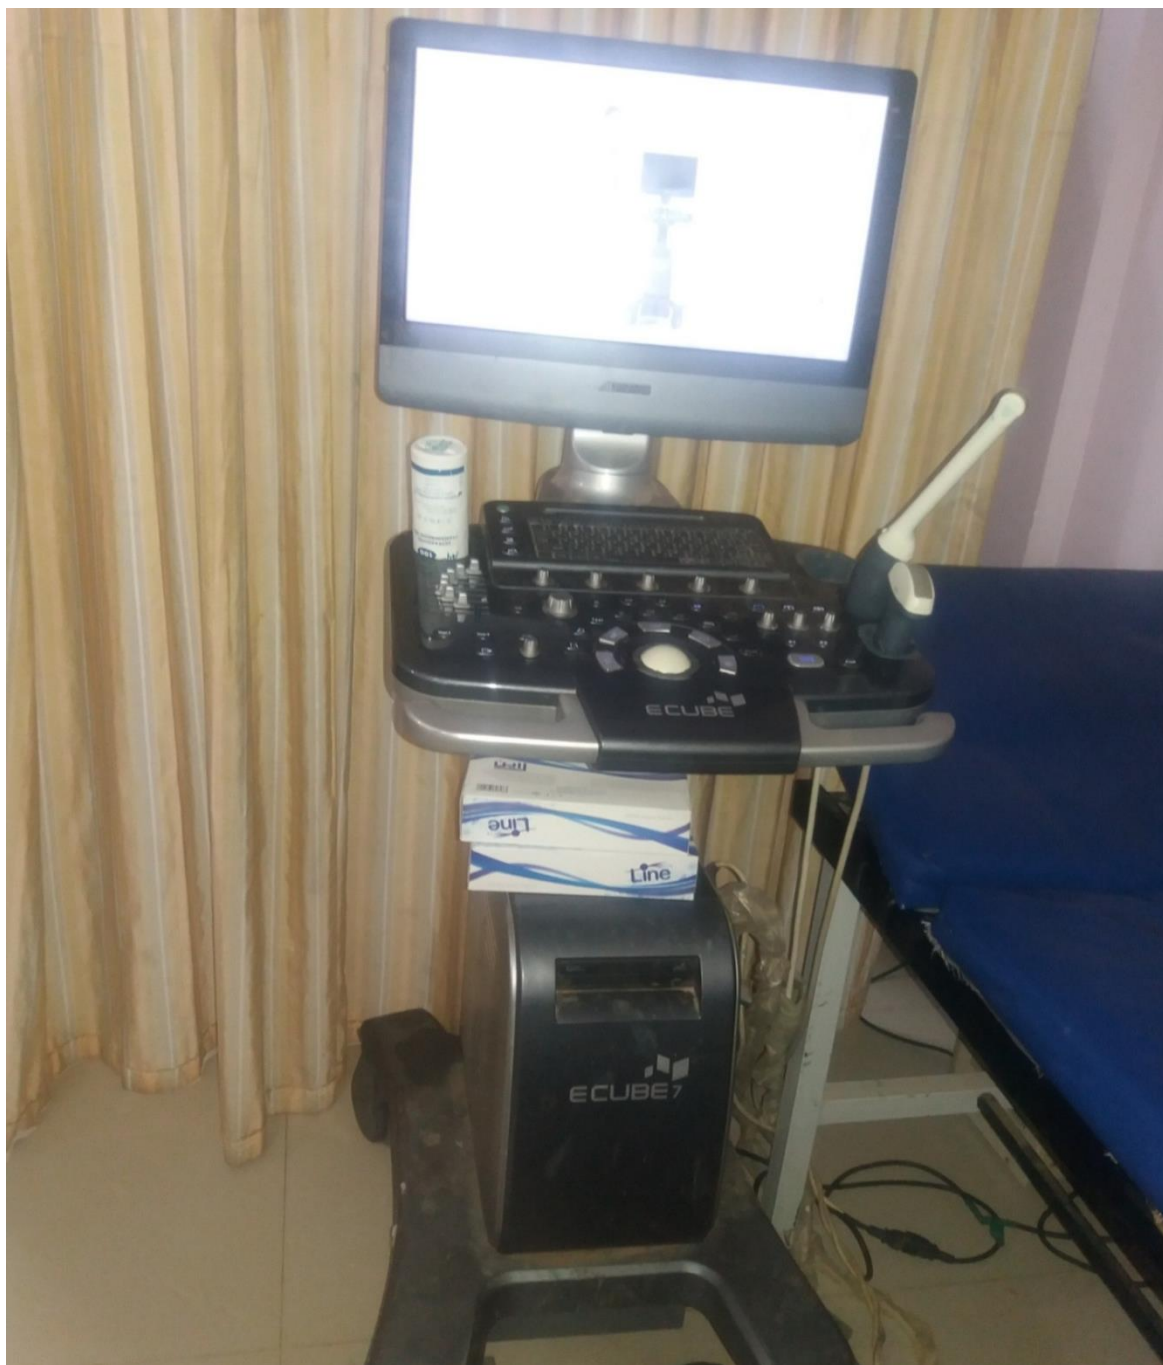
ECUBE ultrasound machine (Author source; 2018).
